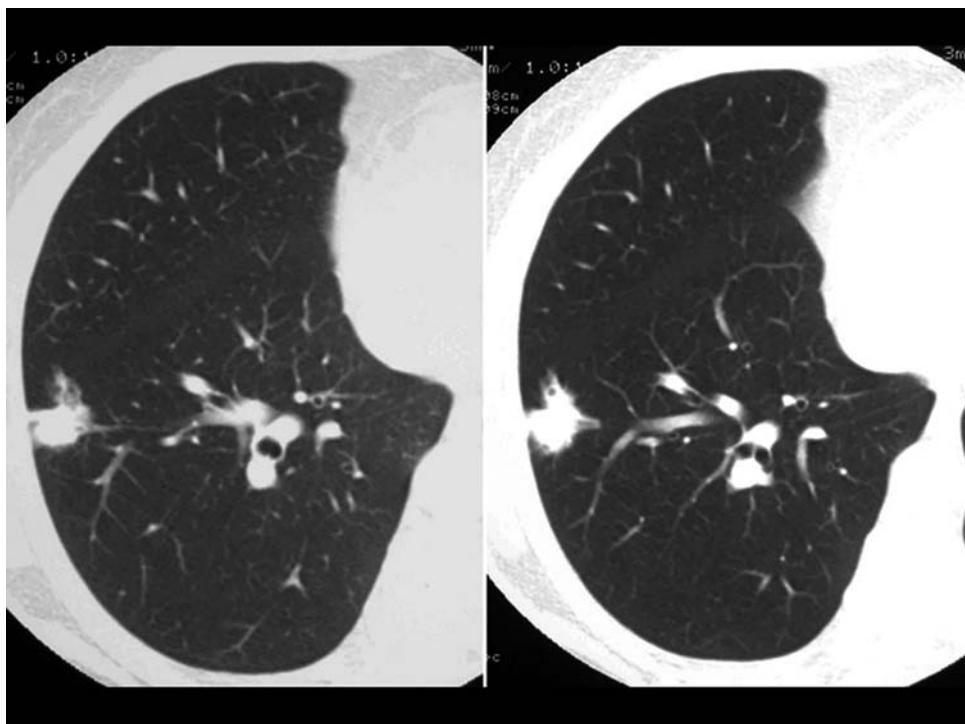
Glandular papilloma, CT of chest showing an irregular nodular opacity measuring about 1.5 cm, in the right lung.
